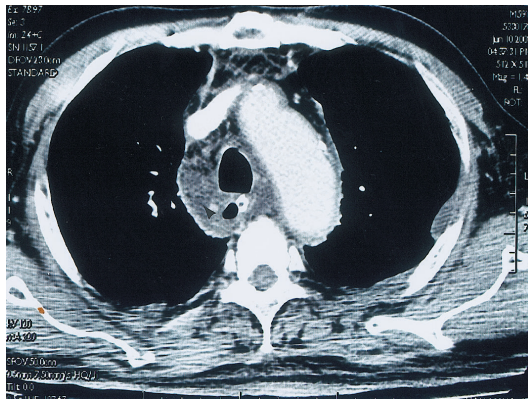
Chest CT shows low attenuation collection and infiltration in the left neck region with extension into the mediastinum adjacent to the esophagus and trachea (arrowhead).
